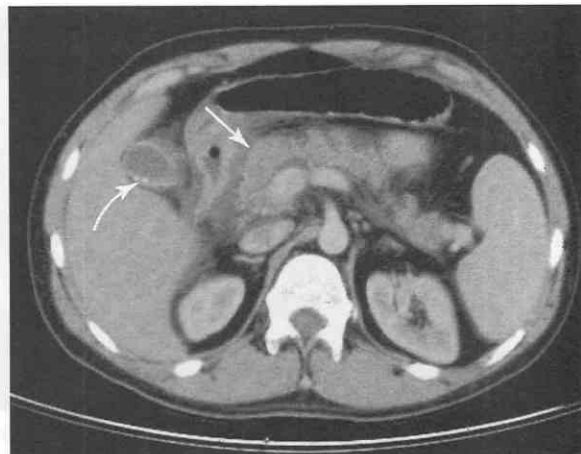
CT scan shows subtle fluid around the body of the gland but early accumulation of fluid in the lesser sac (*arrow*) behind the antrum of the stomach and in front of the pancreas. Also note the small gallstones in the gallbladder (*curved arrow*).
